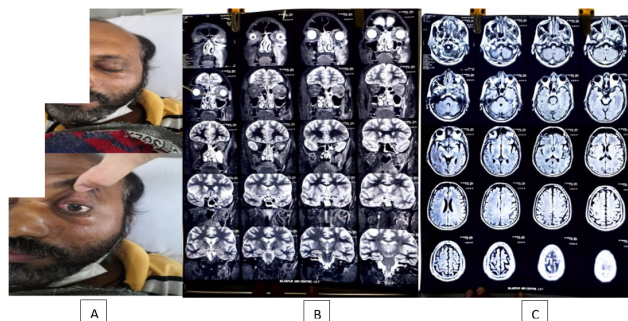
A): Photograph of patient with left eye orbital apex syndrome; B): Patient presented with proptosis, lagophthalmos, conjunctival chemosis, complete ophthalmoplegia and loss of vision; C): Axial magnetic resonance imaging T2-weighted scan showing signs of ethmoid and sphenoid sinusitis with the involvement of left medial rectus muscle and retroorbital fat
